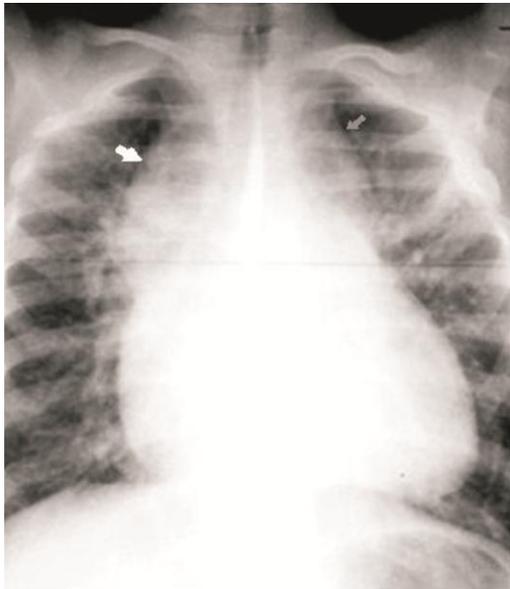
Chest roentgenogram showing supracardiac type of anomalous pulmonary venous connection in a 7 month old infant. The heart has a "snowman shape." The pulmonary veins drain into an enlarged vertical vein (grey arrow), which in turn drains into the brachiocephalic vein and then to the superior vena cava (white arrow).
